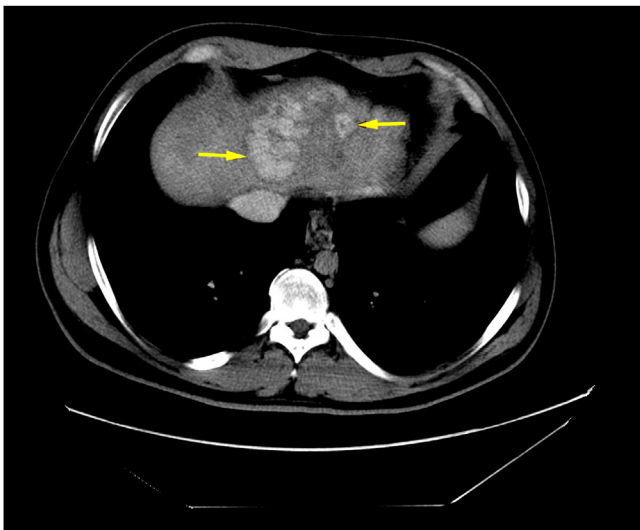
Axial views of a contrast enhanced CT scan of the liver revealing a large heterogenous tumour in the second and third segment of the liver, as signaled by the red arrows.
